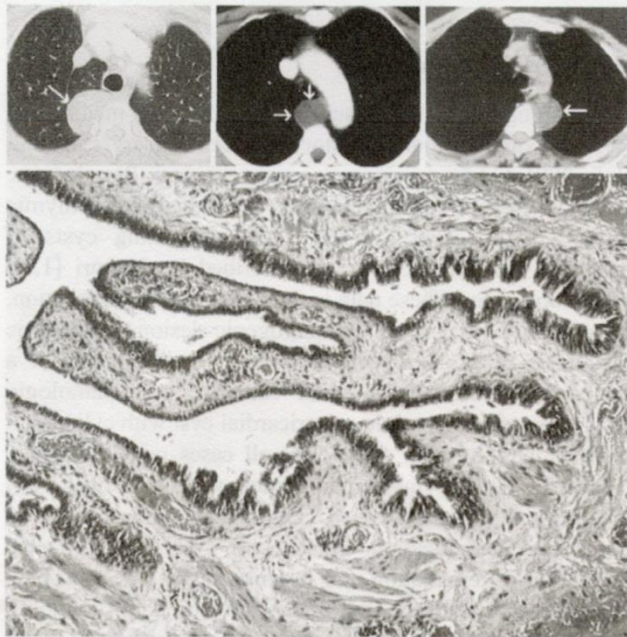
Mediastinal cysts showing müllerian differentiation. (Top, from left) Computed tomographic scan of left paravertebral, prevertebral, and right paravertebral cases. (Bottom) Low magnification of cyst wall forming papillary-like structures lined with cylindrical to cuboidal epithelium and containing bundles of smooth muscle fibers.
